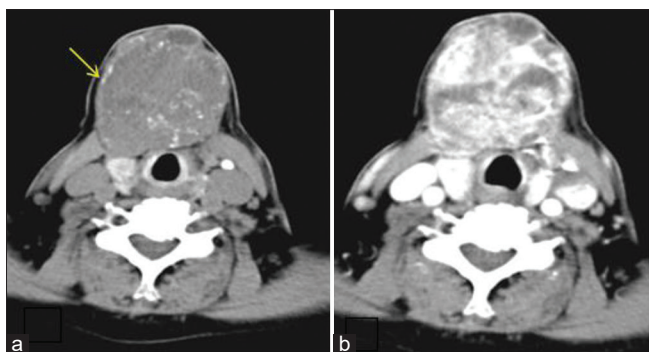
Goitre. (a) Non-contrast CT image shows a large, well-defined soft tissue density lesion with calcifications in the isthmus and left lobe of the thyroid. (b) Corresponding contrast CT image shows heterogeneously enhancing lesions in the isthmus and left lobe
